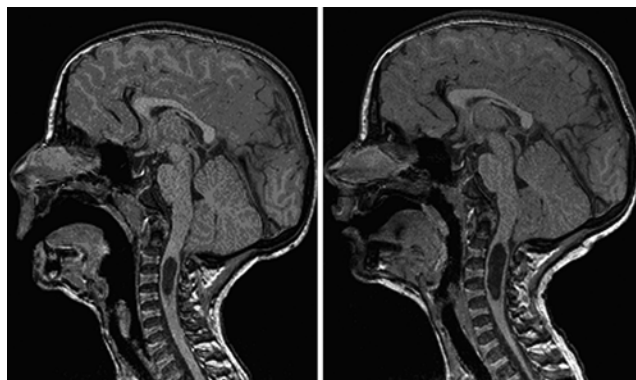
Case 5. Sagittal T1-weighted MR images obtained in a patient with progressive syringomyelia and Chiari Type I malformation at initial (left) and 2-year follow-up (right) examination.
